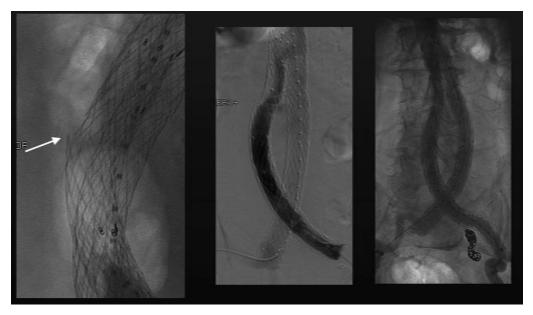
Same patient as Figure 37–2. Left panel is radiograph showing suture pop and stent displacement (white arrow). Middle panel is arteriogram showing fabric defect at the same location. Right panel shows completion angiogram after successful relining.
